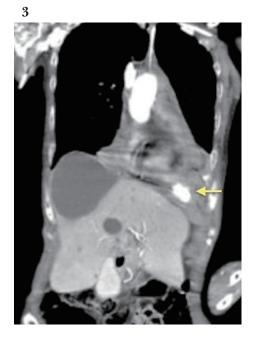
3 Contrast-enhanced CT taken 8 h after arrival at the hospital revealed a hematoma on the left diaphragm, and extravasation.
